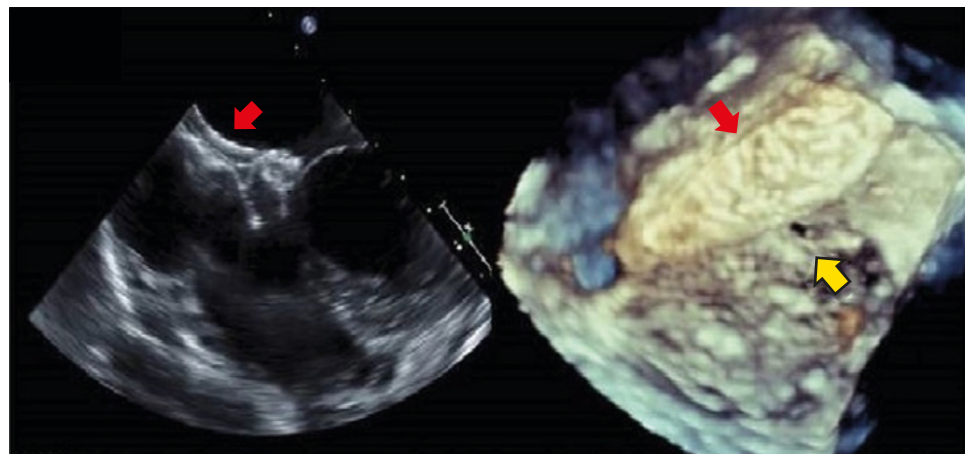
Transesophageal echo showed the atrial septal occluder attached to the anterior mitral leaflet. Yellow arrow indicates the perforated anterior mitral leaflet. Red arrow indicates atrial septal defect closure device.
